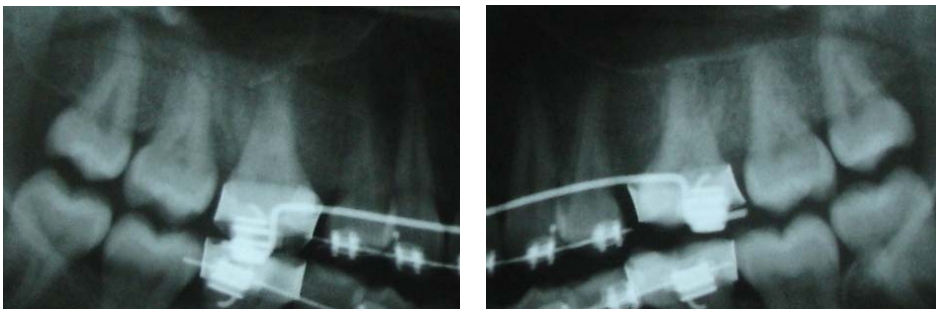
Case 3: Radiographs showing mesially tipped upper right and left first molars
